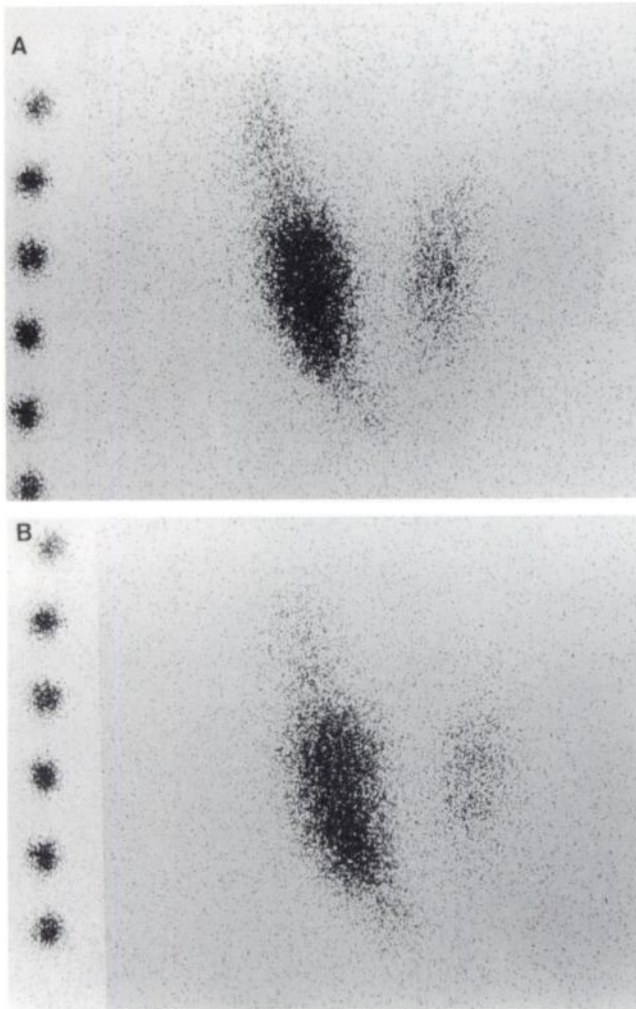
(A) Thyroid scintigram with ^{123}I demonstrates a hot nodule in the right lobe. The rest of the gland shows less radioactivity. The distance between the two point sources is 2 cm. (B) Thyroid scintigram after administration of T_3 reveals the same findings as (A).
